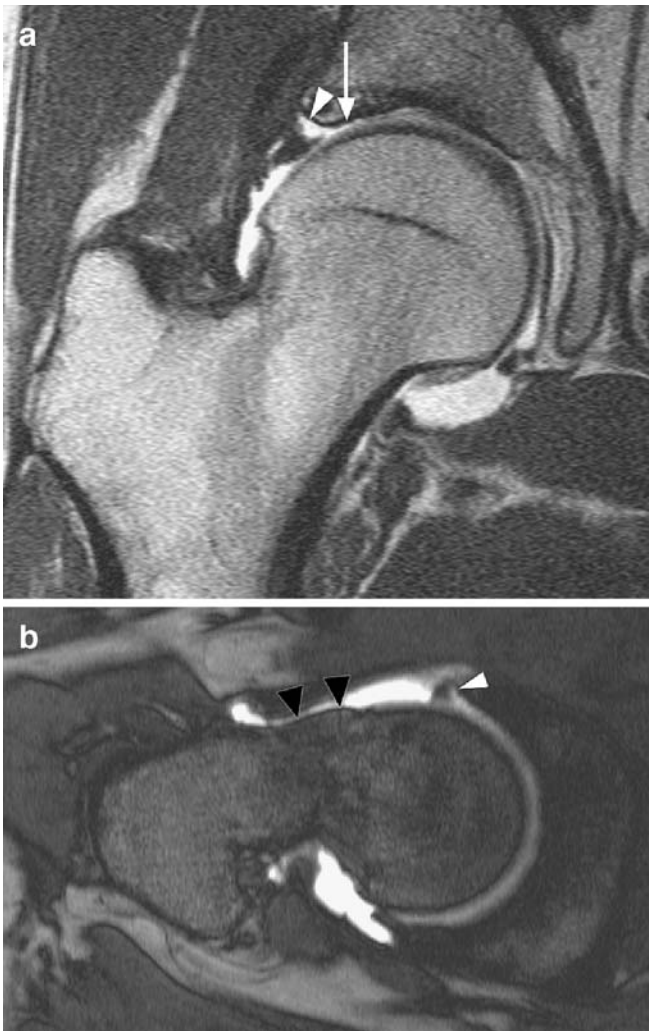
Cam-type of femoroacetabular impingement (FAI). a On the coronal T1-weighted spin echo images (MR arthrogram obtained after injection of 10 ml of 2 mmol/l gadopentetate) superolateral labral detachment (arrowhead) and an adjacent cartilage defect at the acetabulum (arrow). b The angled axial gradient echo image reveals a reduced femoral waist ("offset") with a bony bump (black arrowheads)—a typical finding in cam-type FAI. In addition, a tear of the anterior labrum (white arrowhead) is visible
